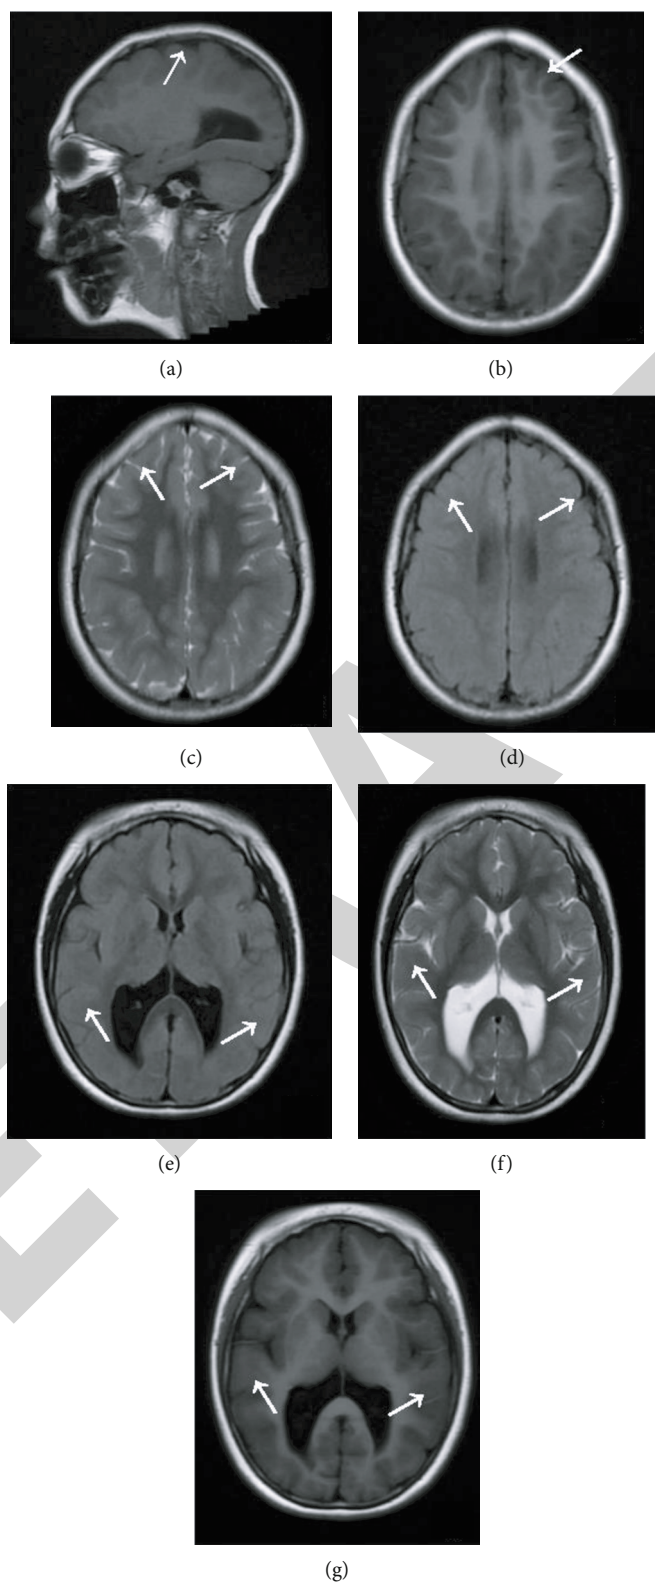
Magnetic resonance imaging of the patient's brain. (a) Female patient aged 8 years and 9 months. Magnetic resonance imaging of the brain showed the gyrus of each lobe of the bilateral cerebral hemispheres is thick, the cortex is thickened, the surface is smooth, the sulci are few and shallow, and the bilateral ventricles are enlarged. The white arrow indicates the deformity of the corpus callosum; (b, c, d) Show the T1W1, T2W1, and T2W1 FLAIR signals of the parietal lobe, respectively; (e, f, g) show the T1W1, T2W1, and T2W1 FLAIR signals of the temporal lobe and occipital lobe, respectively.
